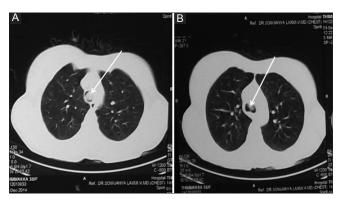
Computed tomography scan chest-white arrow in Panel A shows near total obstruction of tracheal lumen and Partial obstruction of both bronchial lumens at the level of carina in Panel B
